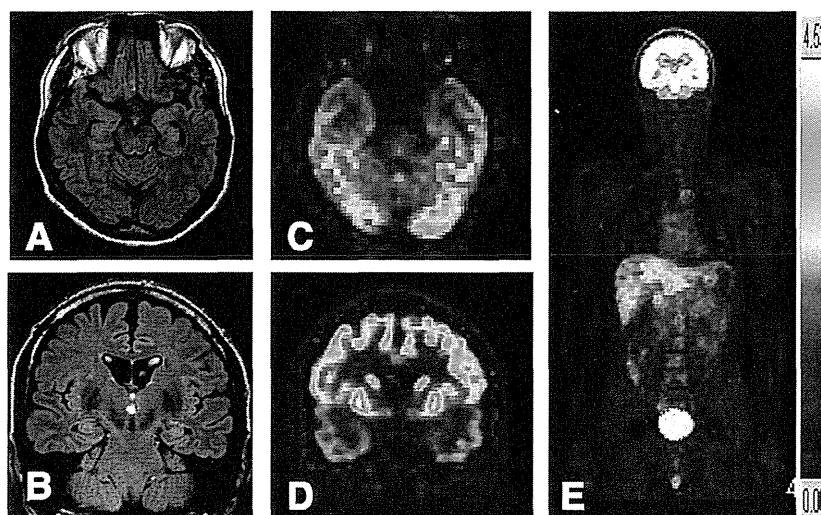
Imaging studies. A: Brain MRI with fluid-attenuated inversion-recovery (FLAIR) sequence, transaxial view. B: Brain MRI with FLAIR sequence, transcorsal view. C: Brain ^{18}F -FDG PET/CT, transaxial view. D: Brain ^{18}F -FDG PET/CT, transcorsal view. Brain images (A, B, C, and D) show no abnormalities. E: Whole body ^{18}F -FDG PET/CT shows no abnormal uptake and excluded underlying paraneoplastic syndrome.
